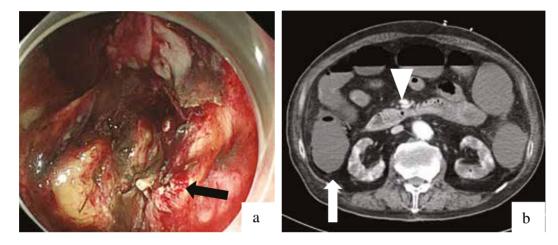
Diagnostic imaging of this patient. (a) First esophagogastroduodenoscopy. The black arrow indicates gastric A1-stage ulcers with visible vessels in the angular notch of the lesser curvature. (b) The abdominal contrast-enhanced computed tomography scan after reintubation. The white arrow indicates decreased contrast enhancement in the colon and air in the colonic wall. The white arrowhead indicates contrast enhancement in the superior mesenteric artery.
